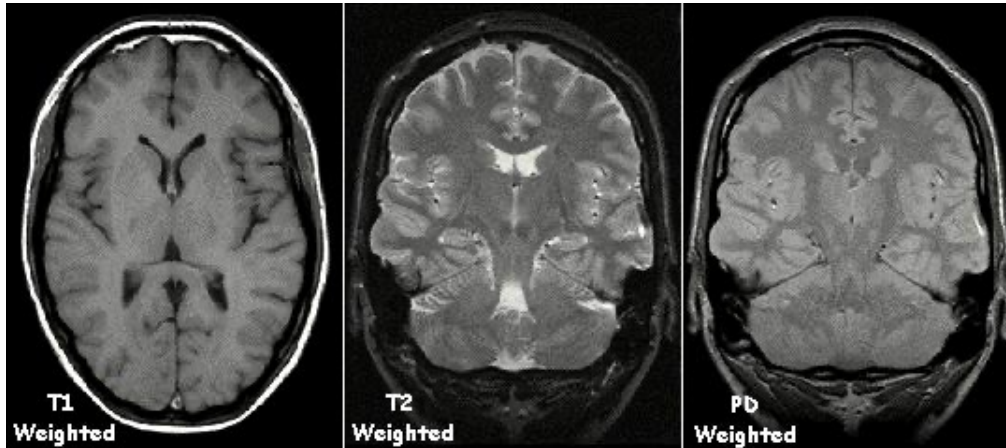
MRI image: T1 weighted image shows a transverse view, the T2 and PD weighted images show a coronal view of a human brain
